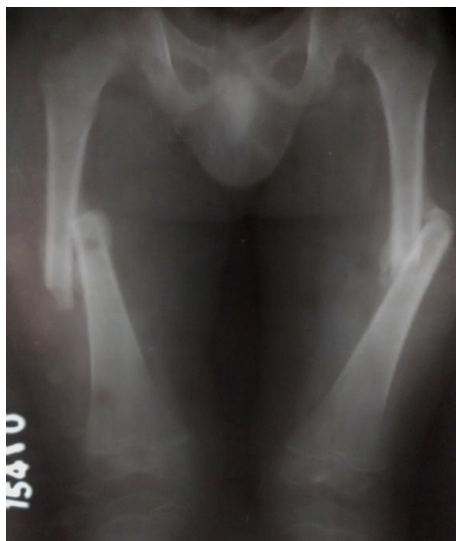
Radiograph showing callus formation in bilateral femur fracture at 3 months follow-up
